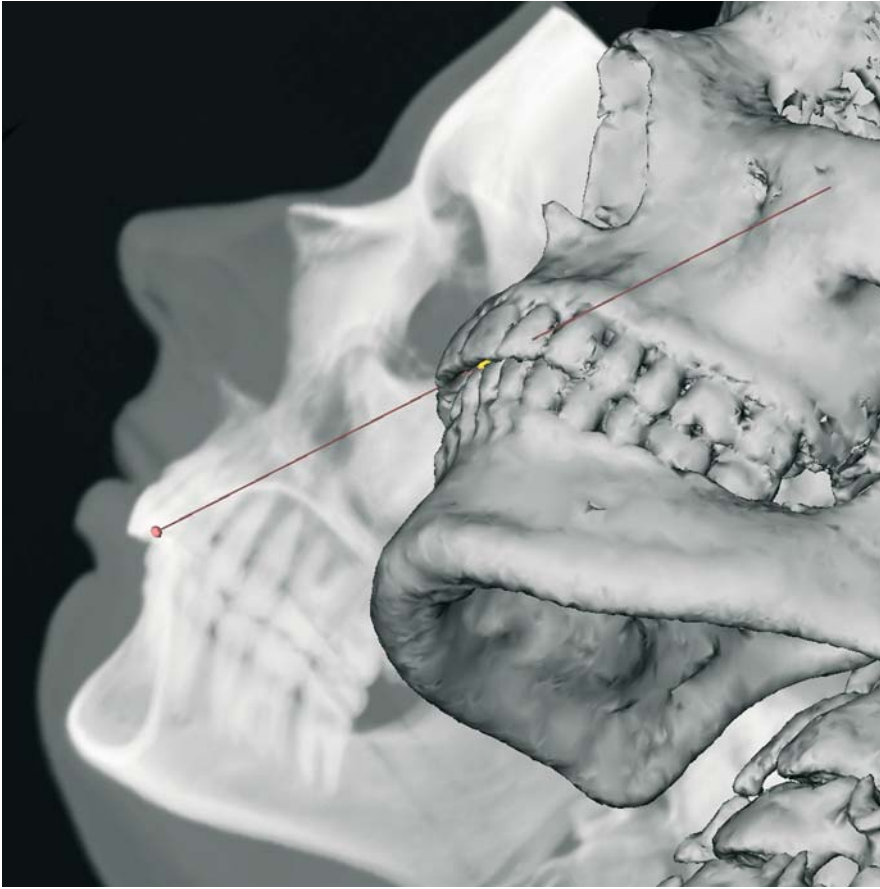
Lower Incisor (LI_r – LI_l) landmarks. Virtual lateral cephalogram linked to the 3-D hard tissue surface representation (3-D CT, patient K.C.)
